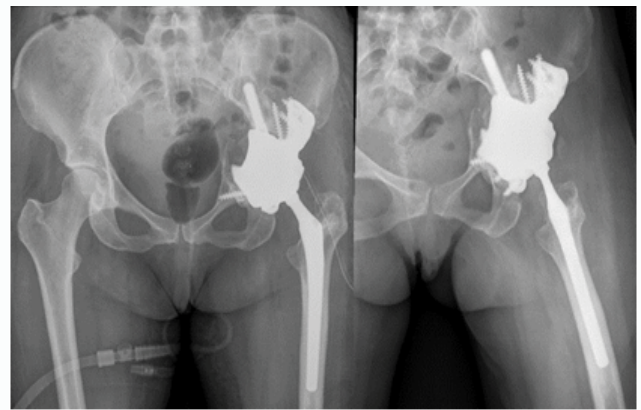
Post-operative control radiographs.
